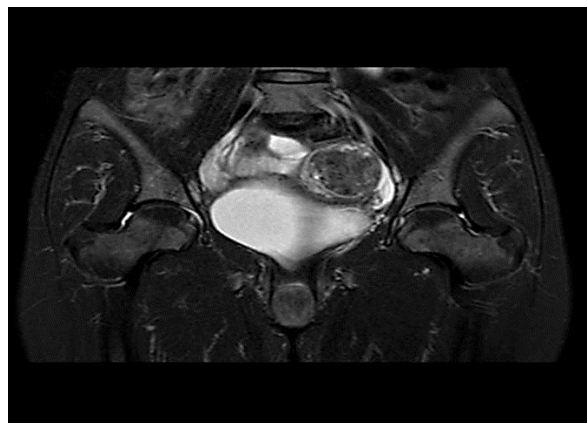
MRI image showing the uterine leiomyoma with well preserved peri-tumoral planes
